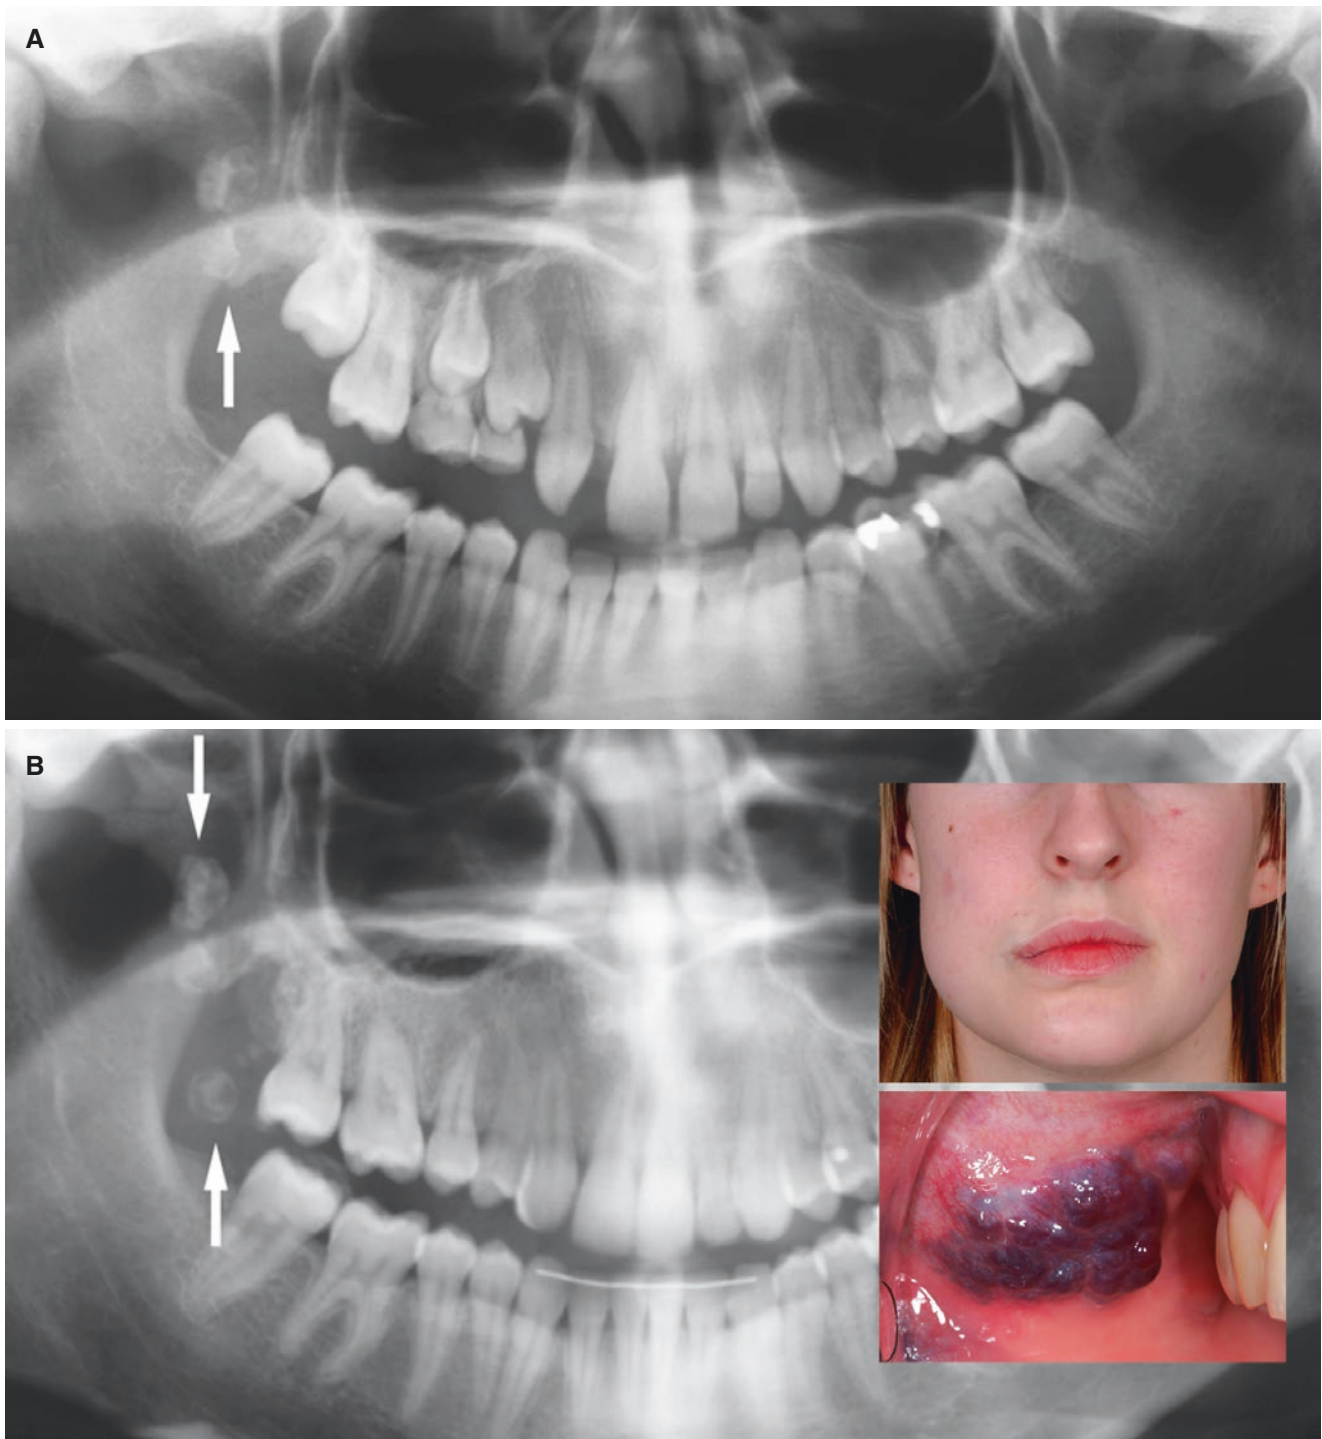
Venous malformation of cheek; 19-year-old female with incidental finding of calcifications on panoramic view that showed progression during a 5-year period. (A) Panoramic view shows calcifications (*arrow*) when the patient was 14 years old. (B) Panoramic view 5 years later shows larger and multiple calcifications (*arrows*). Clinical photographs of the face (*upper*) and oral mucosa (*lower*). (C) Axial CT image shows large calcification just anterior to mandibular ramus
